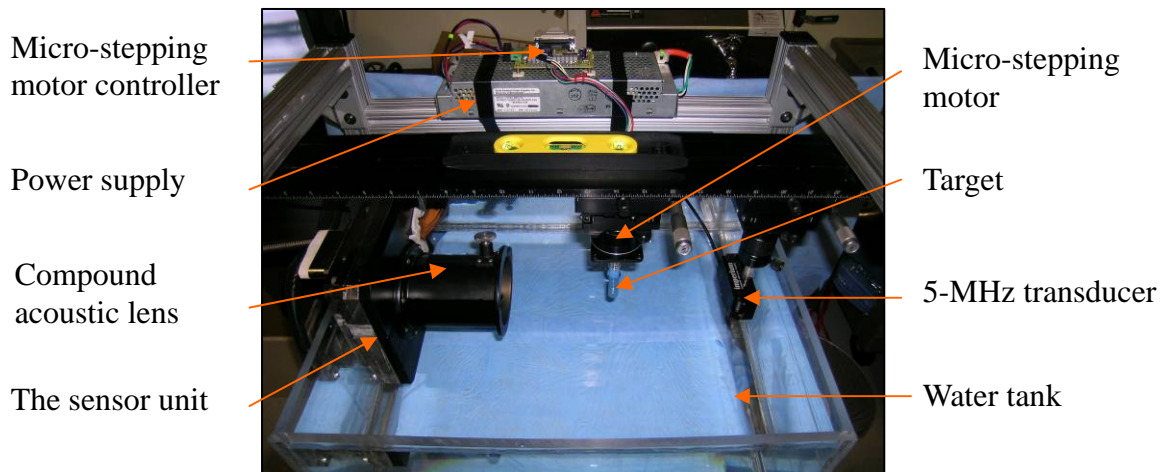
Closer view of the laboratory ultrasound CT system configuration with C-scan prototype #1.
